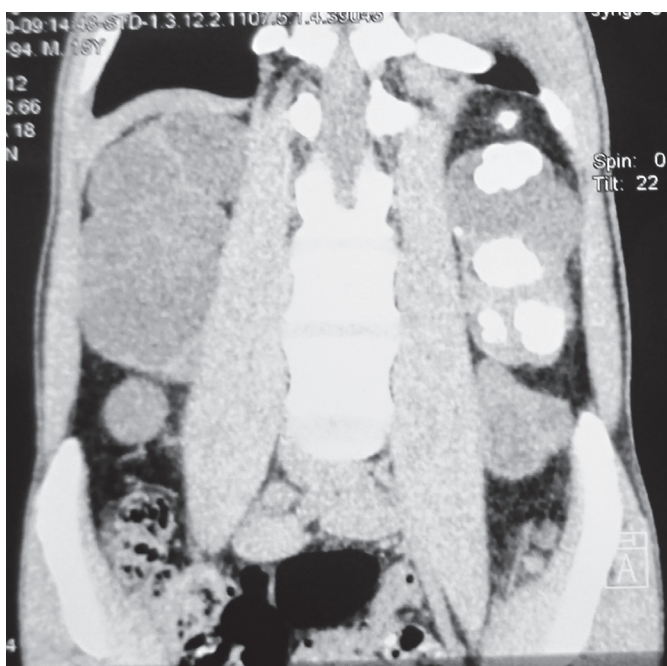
CT scan of the abdomen revealed features of the bilateral hydronephrosis and pelvic urolithiasis.
